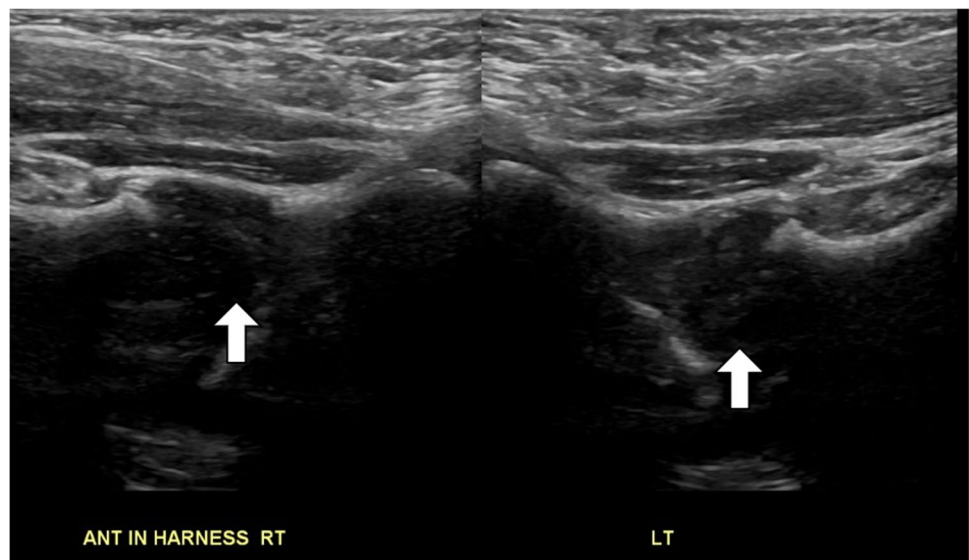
Screening ultrasound in a 3-week-old girl, with an abnormal hip ultrasound, demonstrating a 0.9-cm pubo-femoral distance
